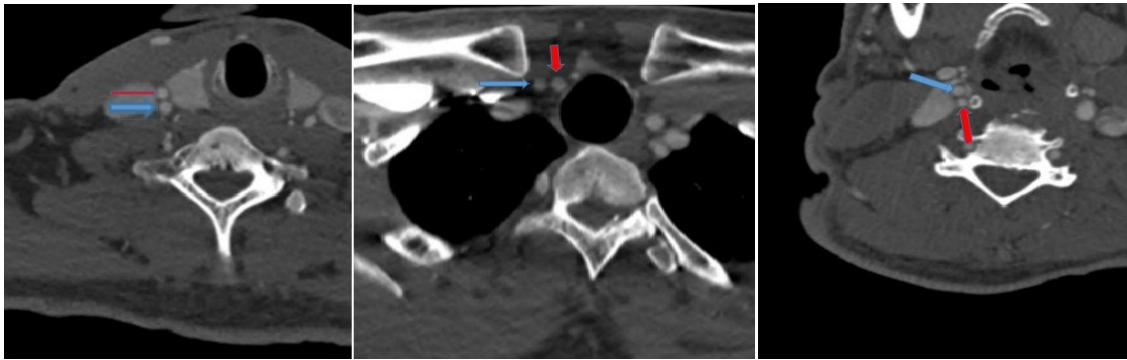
Selected axial, coronal and sagittal source images of neck CTA, from inferior to superior, show separate origins of the right internal carotid artery (ICA red arrow) and right external carotid artery (ECA blue arrow).
